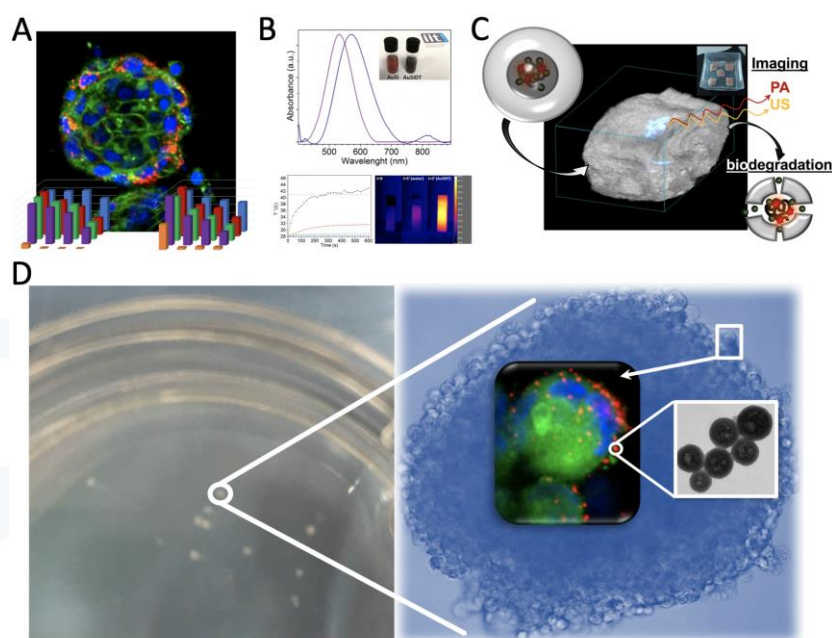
A) Combined image depicting the action of the double endogenous-controlled NAs platform as cisplatin prodrug carrier on cancer spheroids. B) UV/vis spectra of NAs and *thermo* NAs (upper panel) and the photothermal conversion during irradiation in the first biological window (bottom panel). C) Scheme depicting the *ex vivo* employment of NAs as dual photoacoustic/ultrasound (PAUS) contrast agents. D) Micrometastasis-like oral malignancies (left panel) and optical/electronic zooms (right panel).
